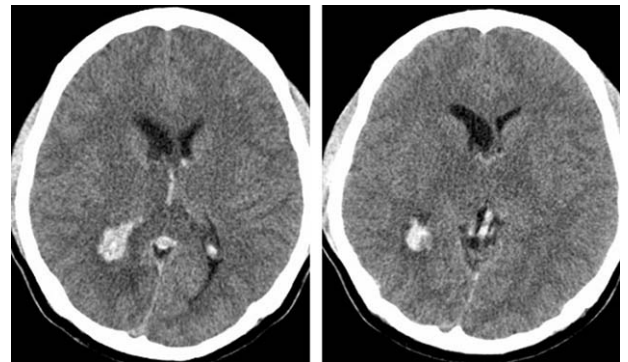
Computed tomography scan showed intraventricular hemorrhage, high density of the vein of Galen, and symmetrical thalamic low densities.
